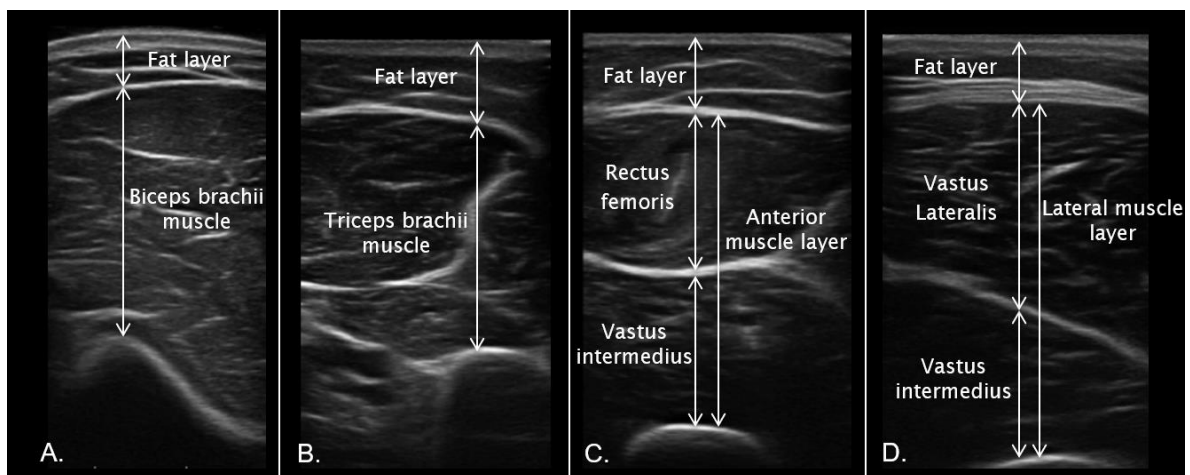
Ultrasound images of the mid-upper arm: A. the anterior side and B. posterior side.; Ultrasound images of the mid-upper leg: C. the anterior side and D. lateral side. For the arm we see the thicknesses of the fat layers, the biceps muscle layer and triceps muscle layer. For the leg we see the fat layers, the rectus femoris, vastus intermedius, vastus lateralis, anterior muscle layer and the lateral muscle layer.
